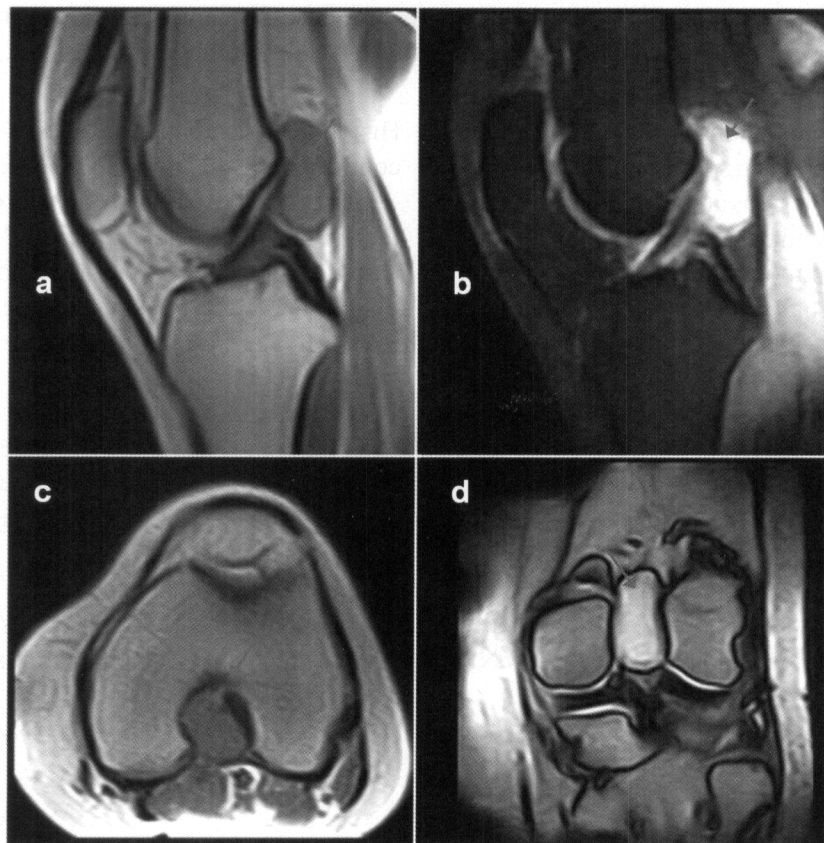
a)* Sagittal T1- and T2-weighted MRI *(b)* showing a defined mass, with cystic appearance, localized in the posterior aspect of the ACL. *c)* Transverse and coronal views *(d)* showing a mass occupying the intercondylar notch with posterior extension. No other lesions are evident.
